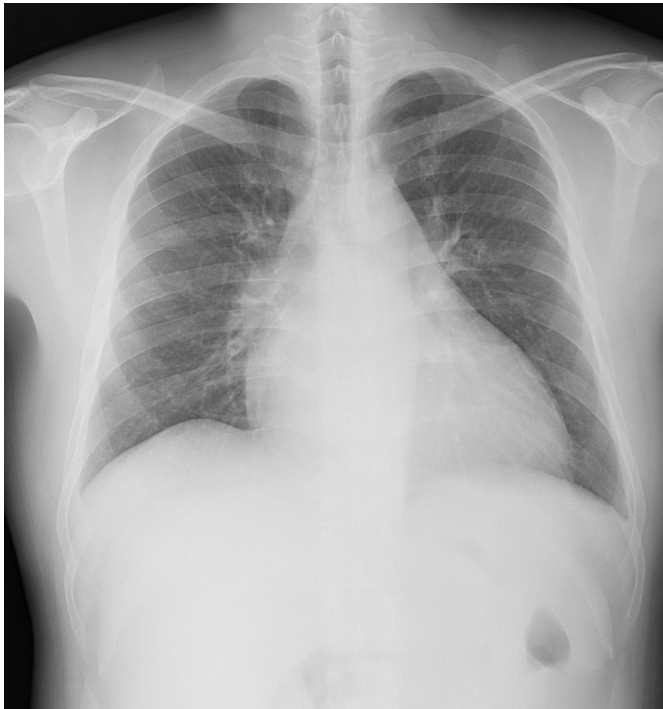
Chest X-ray shows cardiomegaly and no pulmonary edema.
